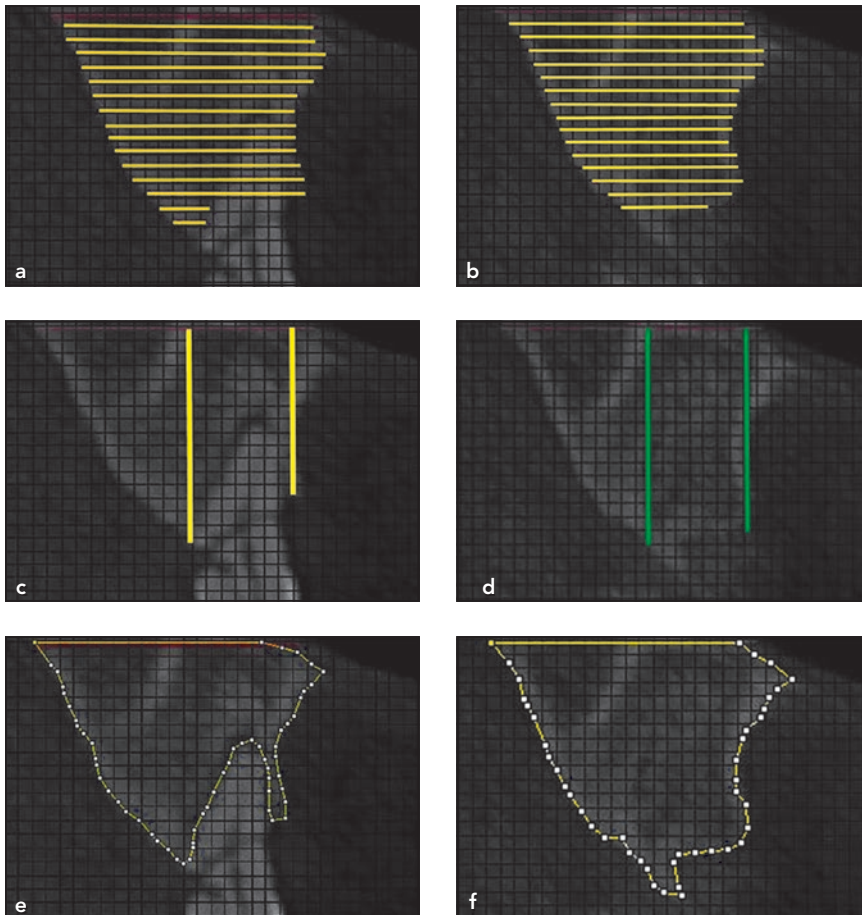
Radiographic evaluation protocol. (a) Baseline socket dimension (OV). (b) Postoperative OV. (c) Baseline vertical socket dimension (VER). (d) Postoperative VER. (e) Baseline socket area (SA). (f) Postoperative SA.
